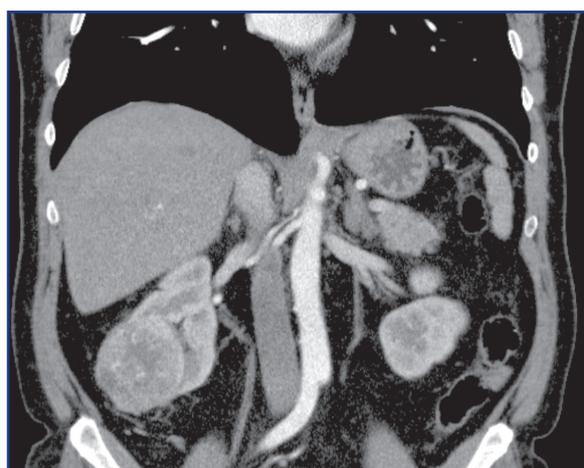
Abdominal CT with the tumor in the lower pole of the right kidney, involving the calyx-pelvic segment.
